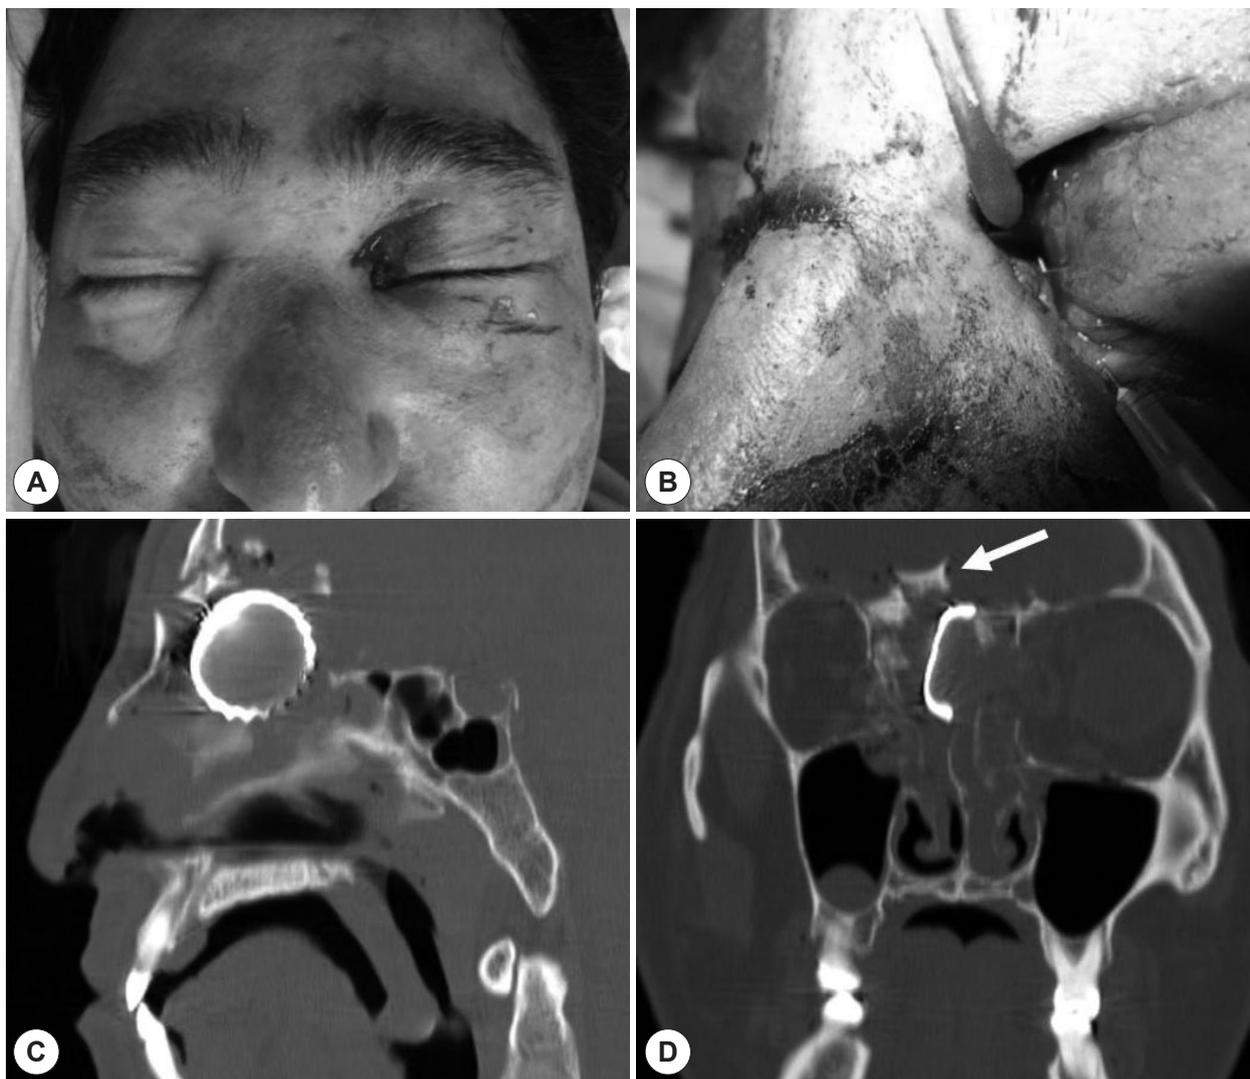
A: Entry wound over the left medial canthus. B: Needle probing showing canalicular injury and medial canthal laceration. C: Sagittal computed tomography (CT) scan showing a bottle cap in the anterior ethmoid sinus with anterior skull base disruption. D: Coronal CT scan showing bilateral medial orbital wall fracture with displacement of the crista galli and cribriform plate (white arrow).
